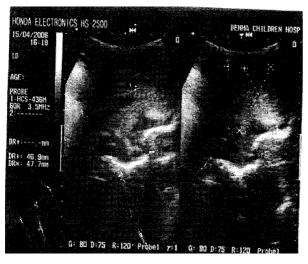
Cranial ultrasound is consistent with I.V.H.grad IV.
